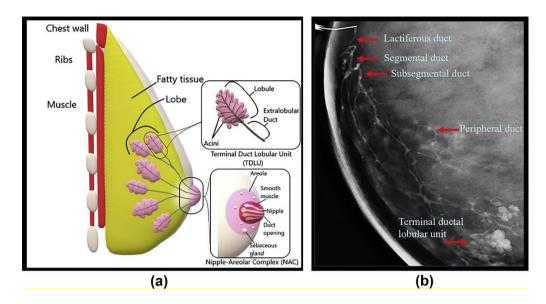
a) sagittal section of breast in a pictorial presentation b) MRI image of a normal breast
